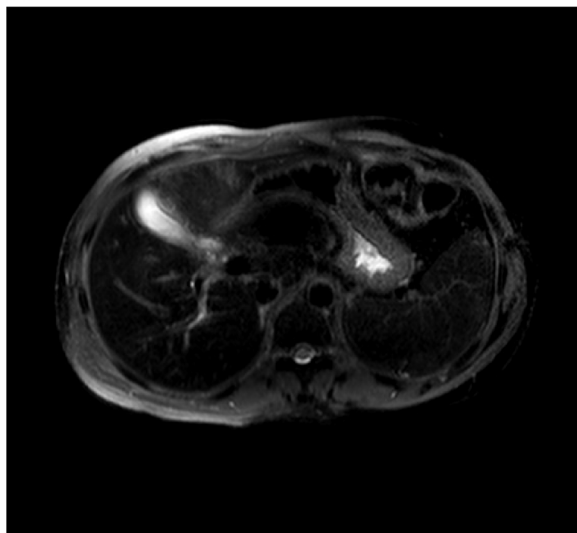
A: T1 weighted MRI of the pancreas showing enhancement and collection. B: T2 weighted MRI of the same area.
